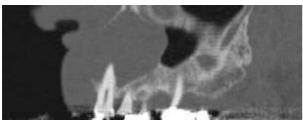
Sagittal CT scan shows expansion of the tumor in maxillary sinus
